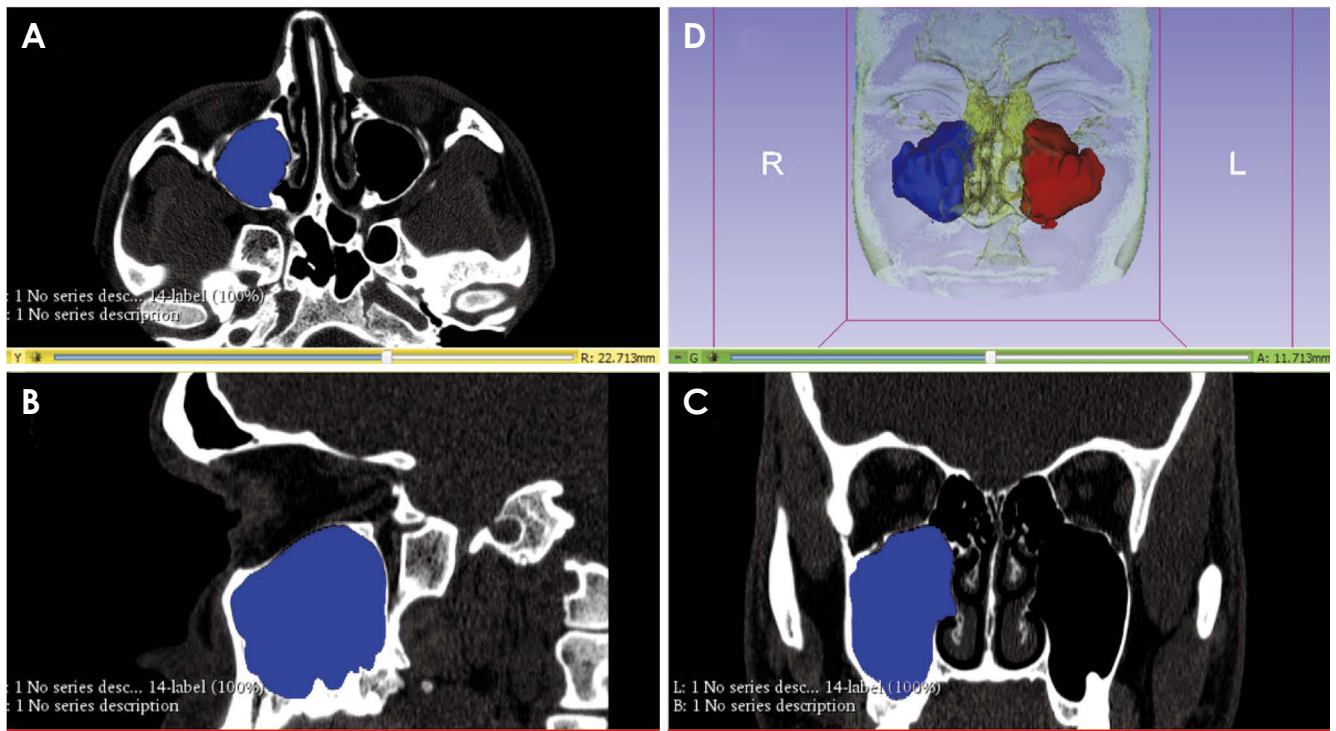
Images from the sample of the present study taken using 3D Slicer software. A: Computed tomography shows the maxillary sinus in an axial slice. B: Computed tomography shows the maxillary sinus in a sagittal slice. C: Computed tomography shows the maxillary sinus in a frontal slice. D: 3D reconstruction presents the right maxillary sinus in blue and the left maxillary sinus in red.
